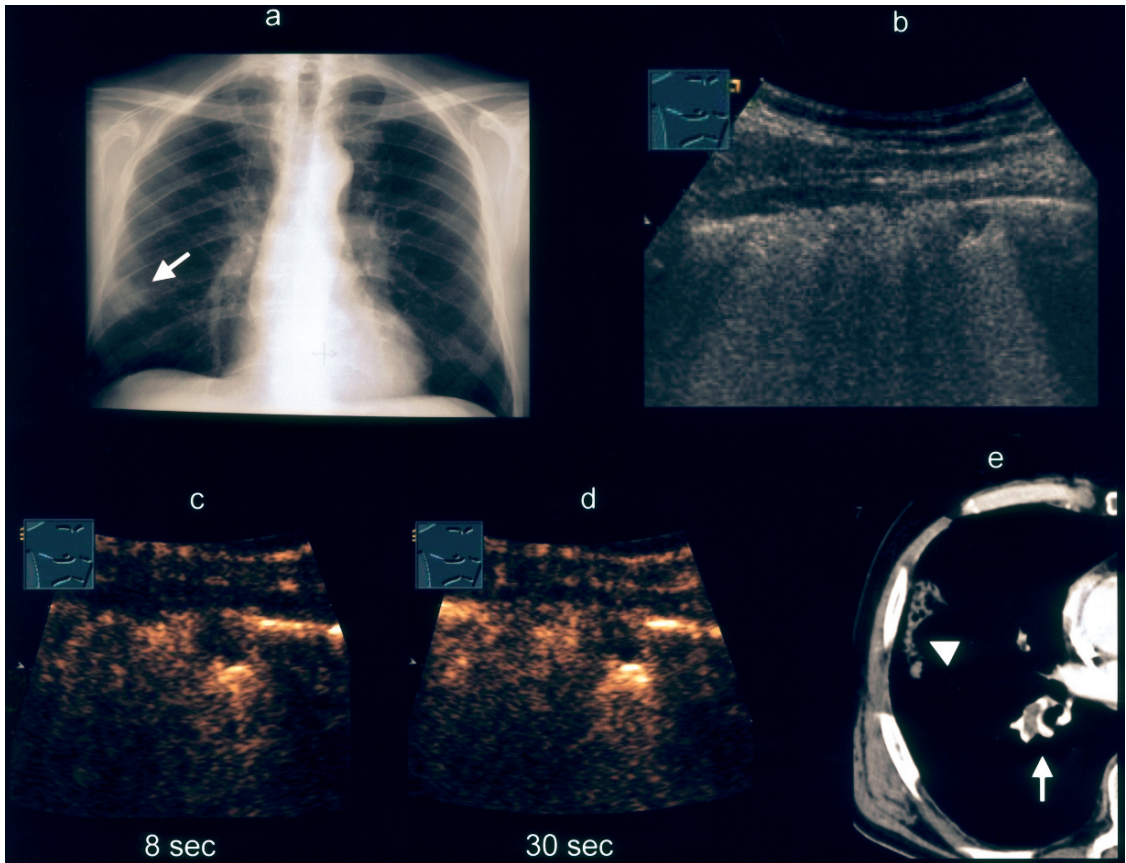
Sixty-four year old male patient with dyspnea and breath dependent right sided pleural pain. A: X-ray of the chest shows right sided pleural lesion (arrow). B: B-mode sonography shows a small round hypoechoic pleural lesion (arrow). C: Contrast enhanced sonography shows no enhancement after 8s indicating lost of pulmonary arterial supply. D: After 30s no enhancement of the lesion is seen indicating absence of bronchial arterial supply. The area of no enhancement suggests evidence of pulmonary embolism. E: Contrast enhanced computed tomography confirms diagnosis of a central pulmonary embolism (arrow) with a peripheral lesion (stick)
